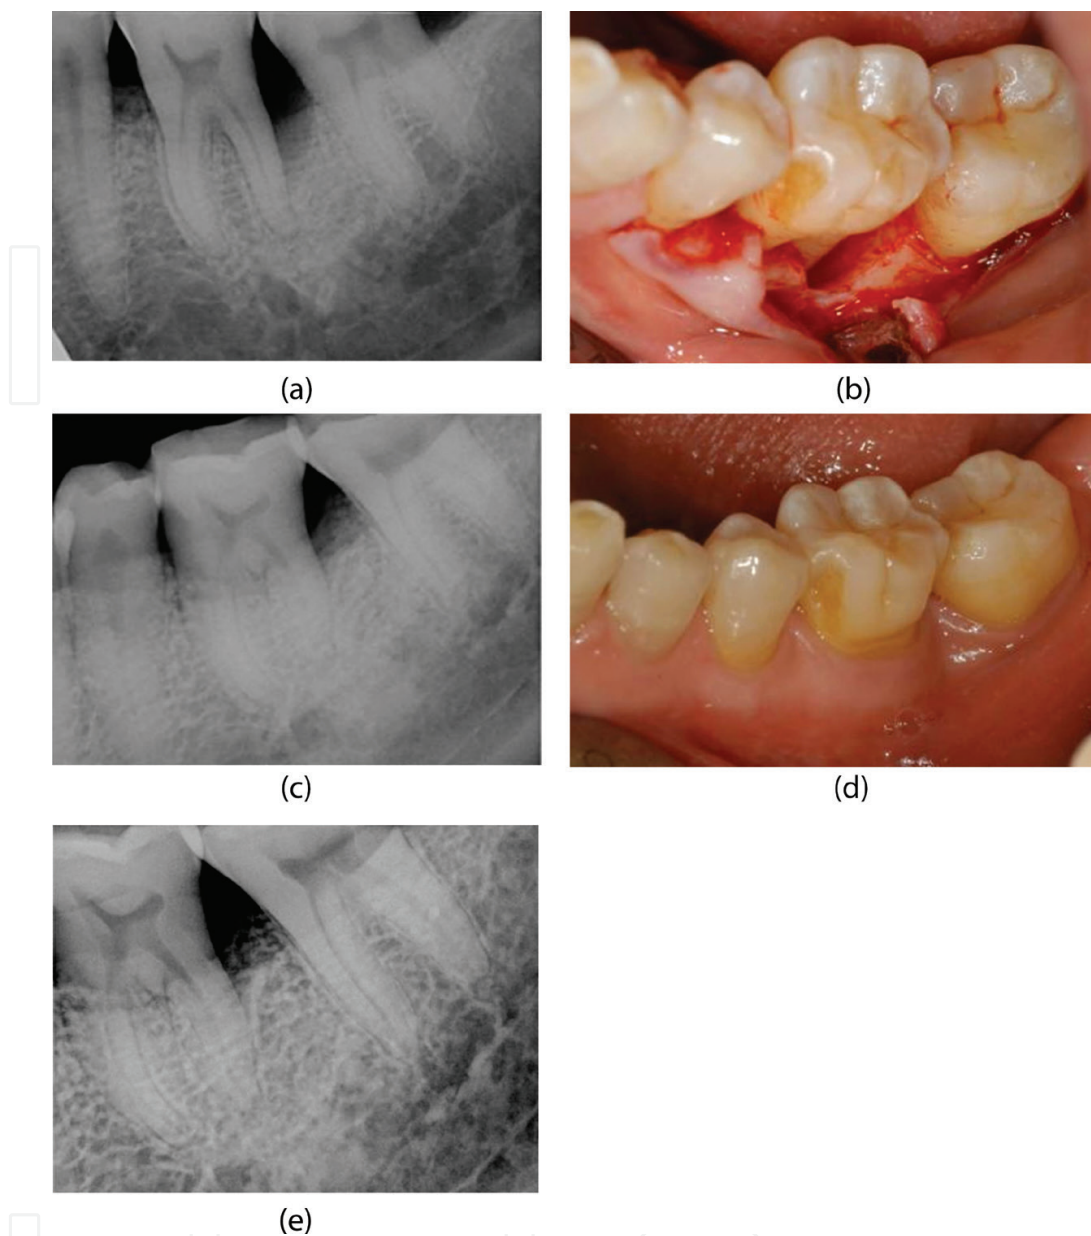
Regeneration of the defect area with enamel matrix only. (A) Preoperative periapical radiograph of the mandibular left first molar with loss of supporting bone in the distal area. (B) Buccal view after elevation of a full thickness flap, showing the loss of alveolar bone in the distal root area. (C) Ten-month postoperative clinical view indicating the uneventful healing. (D) Ten-month postoperative radiograph. (E) The radiograph at 1 year and 11 months postoperative, showing increased radiopacity in the distal root area.
